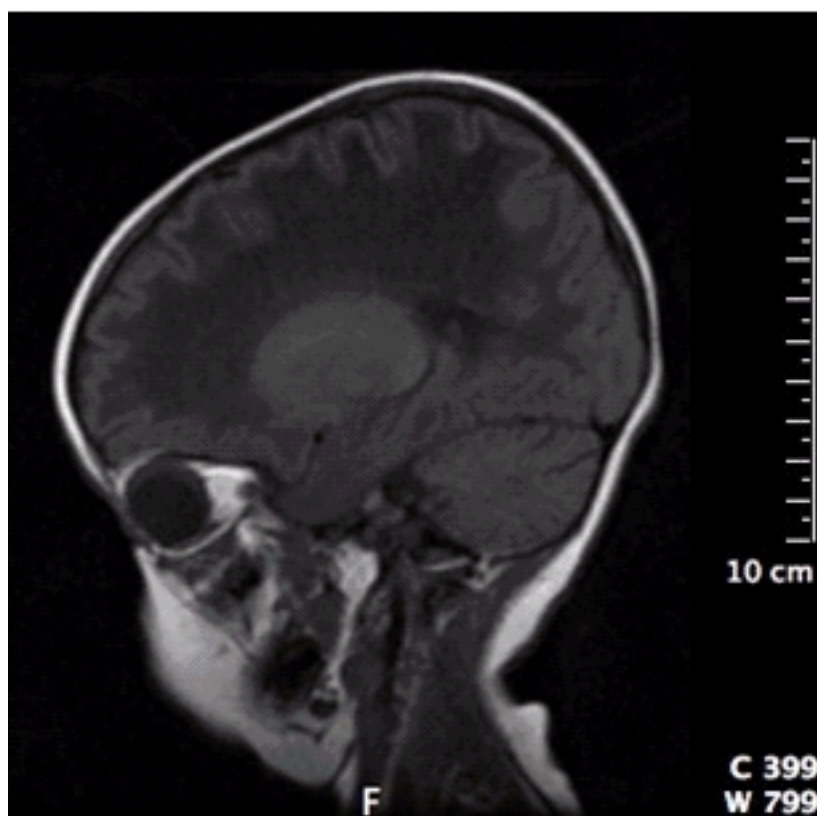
Parasagittal T1-weighted MRI image of an individual with CACH shows diffuse hypointensity of the white matter interrupted by a typical meshwork of remaining tissue strands radiating across the abnormal white matter.
